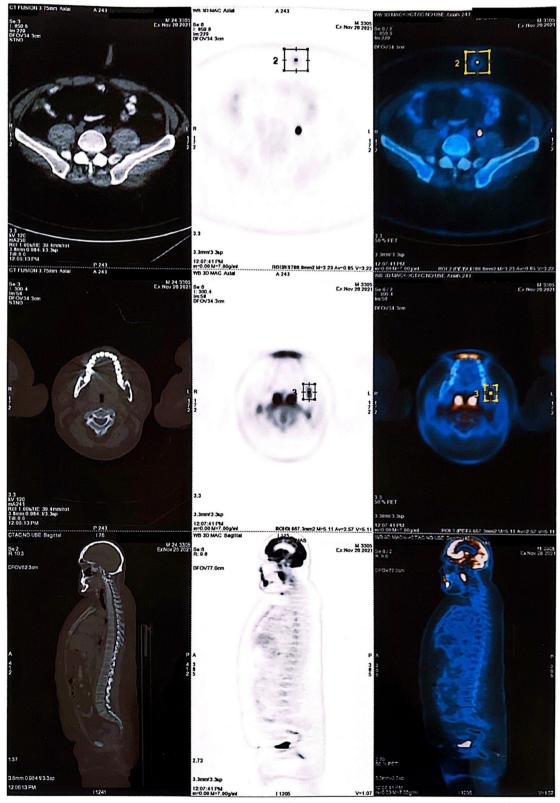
Hypermetabolic lytic lesions in positron emission tomography with fluoro-2-deoxyglucose and computed tomography from vertex to mid-thigh. Prominent hypermetabolic palatine tonsils are evident
